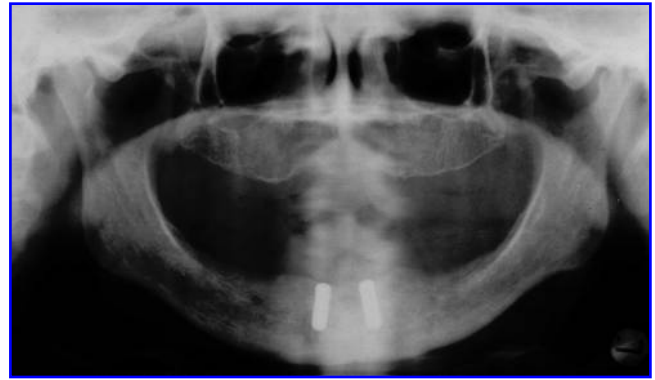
Orthopantomographic: two dental implants *in situ*.
